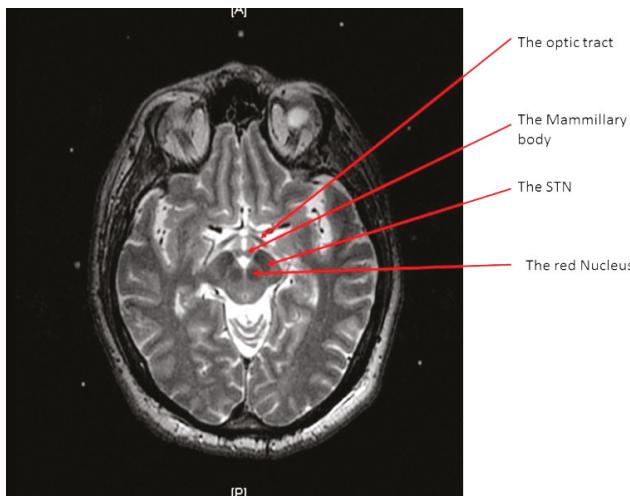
An axial T2 weighted magnetic resonance imaging (MRI) image at the level of the subthalamic nuclei (STN).
